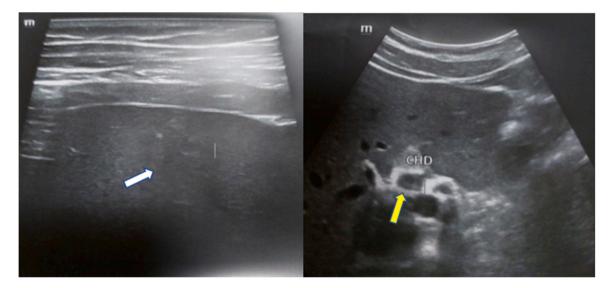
Ultrasound images the liver of a patient with Fasciola hepatica. The images show peripheral ill-defined heterogeneous echogenicity in the right hepatic lobe (white thick arrow) and common hepatic duct wall thickening (yellow arrow).
